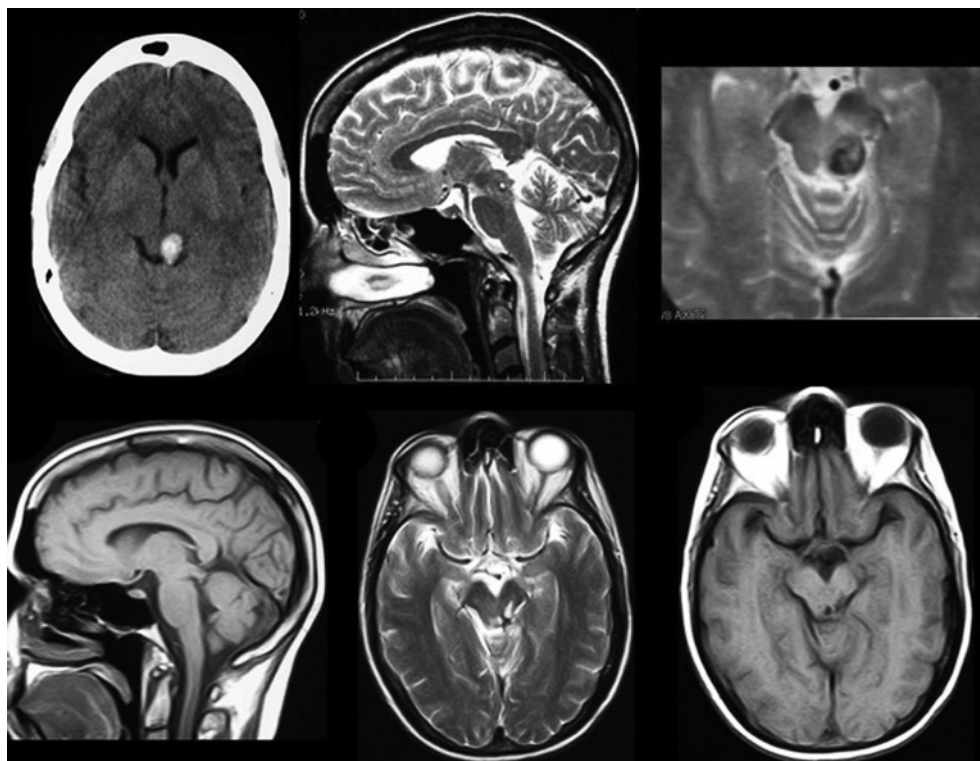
Top, preoperative MRI of a dorsal midbrain cavernous malformation exposed through a supracerebellar infratentorial approach. Bottom, postoperative MRI documenting resection of the malformation.
